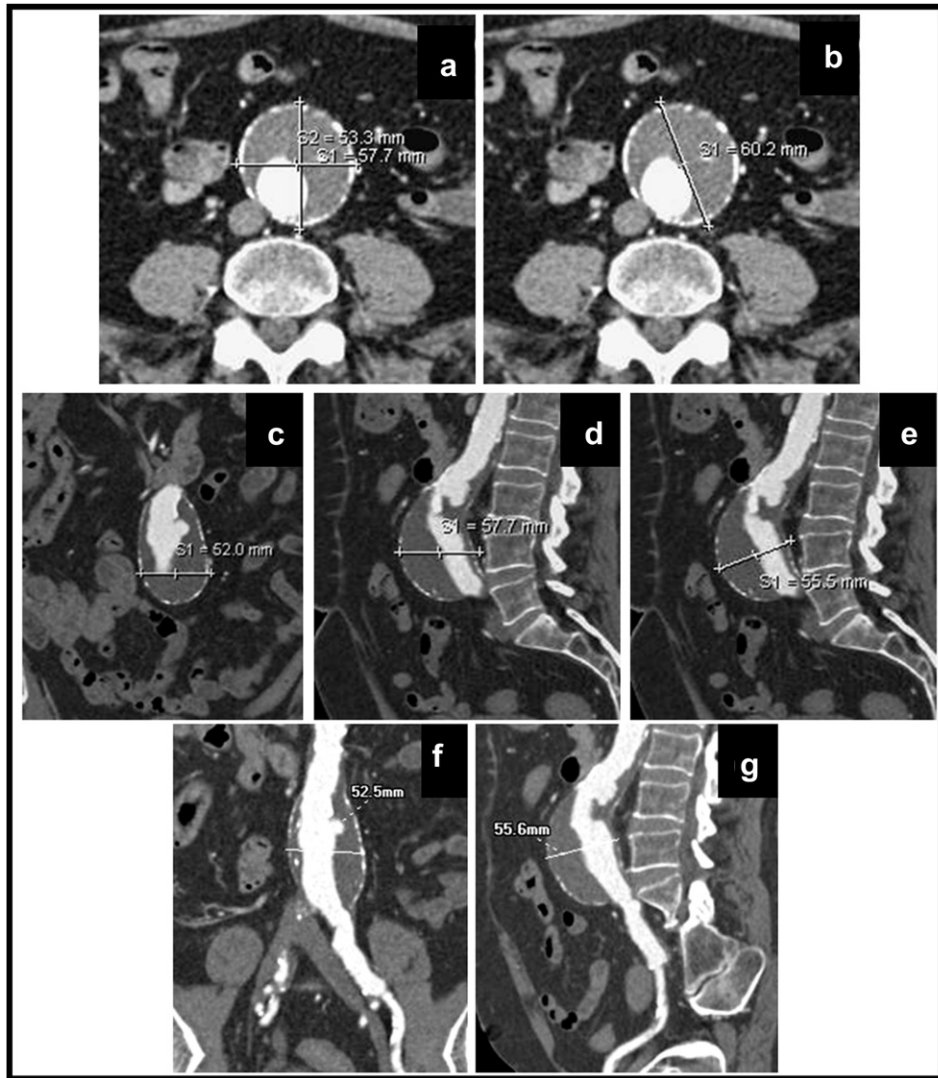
Diameter measurements on CT views for the same patient as in Fig. 2. a) Axial plane; S1 : anteroposterior diameter; S2 : transverse diameter. b) Axial plane; S1 : maximum diameter in any direction. c) Coronal plane; S1 : transverse diameter. d) Sagittal plane; S1 : anteroposterior diameter. e) Sagittal plane; S1 : maximum diameter perpendicular to the centreline. f) Curved MPR; maximum diameter perpendicular to the centreline. g) Curved MPR; maximum diameter perpendicular to the centreline.
